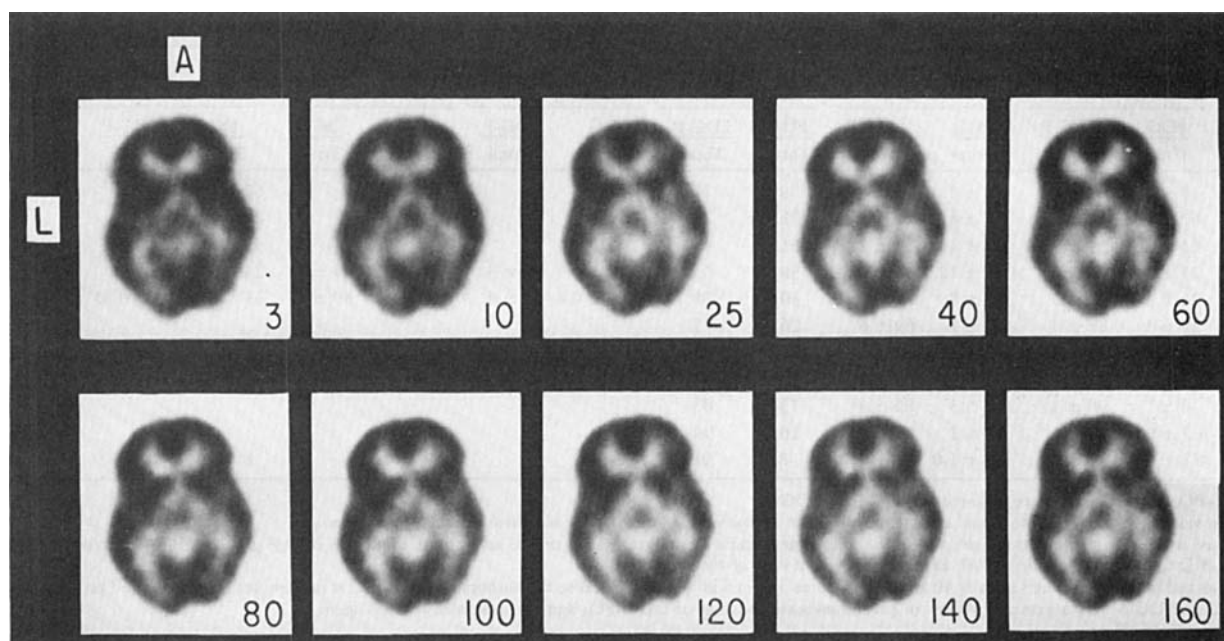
A single cross-section of the head as a function of time for determination of stability and precision of measurement of CMRGlC with FDG. Mid-times of scans are shown below images. The images shown were selected from a total of 30. Level is 3.5 cm above the orbital meatus (level of basal ganglia). L is
